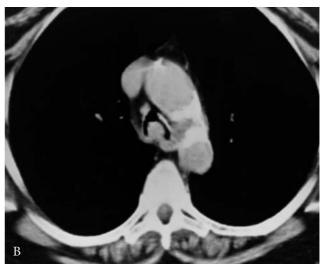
Squamous cell carcinoma of the trachea. Posteroanterior chest radiograph (A) and computed tomography scan of the distal trachea (B) reveal a round soft tissue mass arising from the posterior wall of the trachea.
